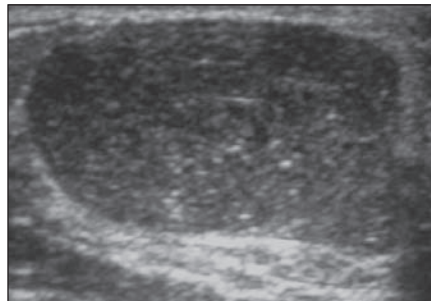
14-year-old girl with palpable breast mass. Sonogram shows well-defined hypoechoic heterogeneous 7-cm mass with tiny echogenic foci and increased through-transmission. Excisional biopsy revealed benign phyllodes tumor.
